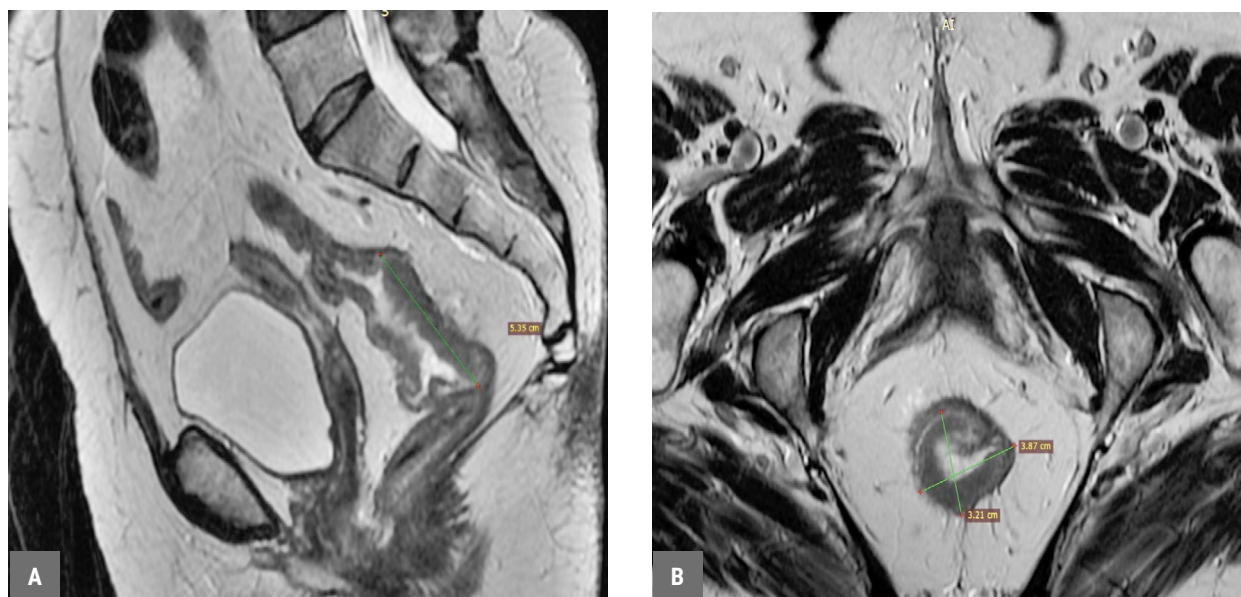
MRI of the pelvic organs: a tumor of the middle ampullary rectum with a spread to the upper ampullary $7.5 \times 2.4 \times 4.3$ cm, at a distance of 8.1 cm from the anus, with lesion of mesorectal lymph nodes (a) sagittal section, (b) frontal section.
